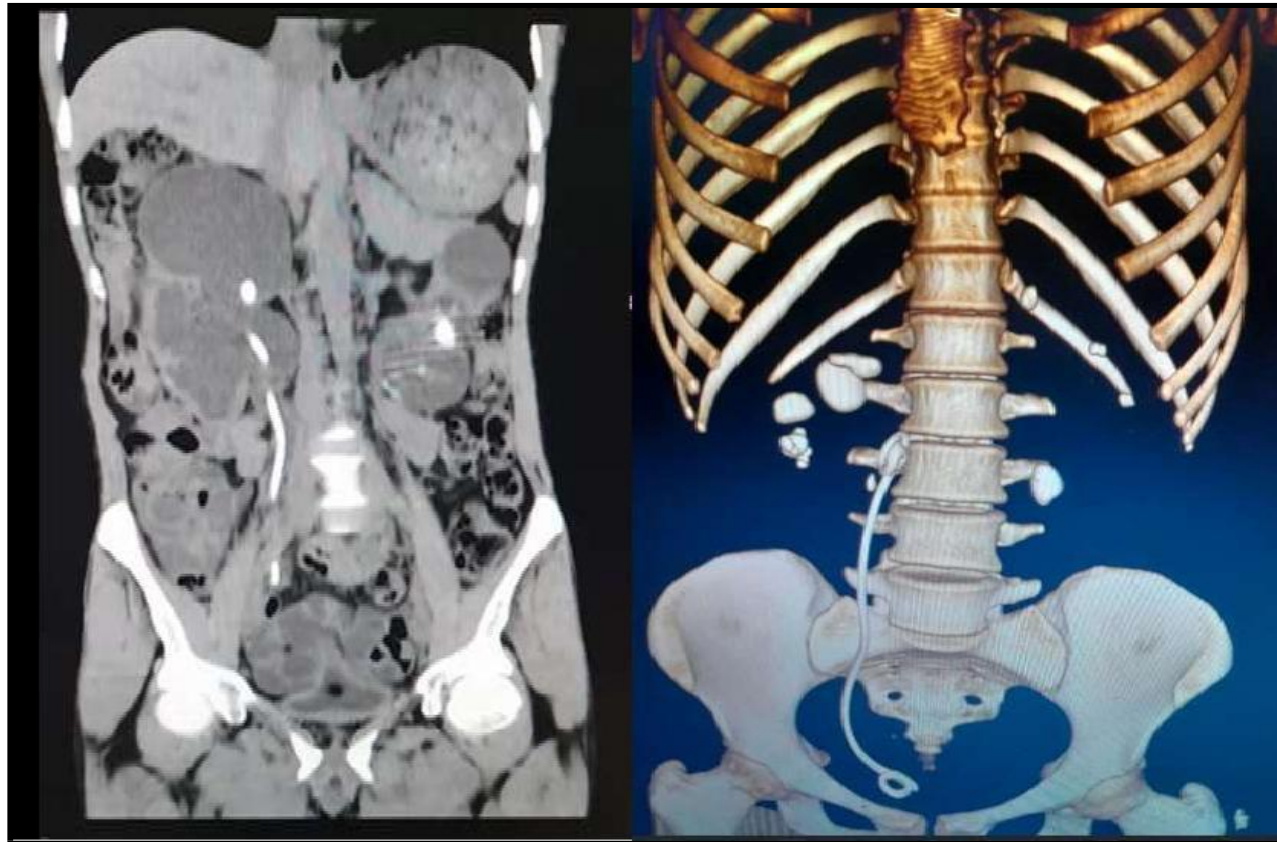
Coronal and three D view CT scan of abdomen shows right ureter J-stent insitu
